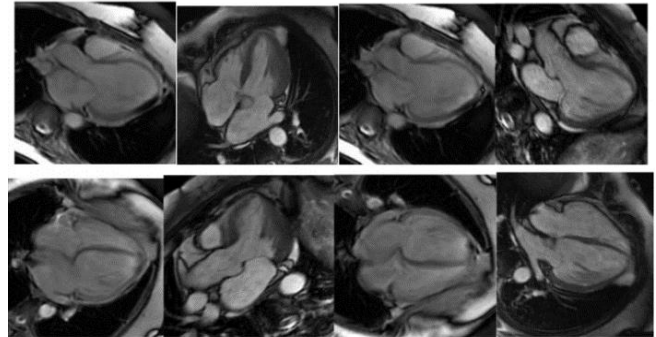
Image: Cardiac magnetic resonance image of non-compaction left ventricle with functional improve after a 6-month treatment with sacubitril/ valsartan¹⁴.
